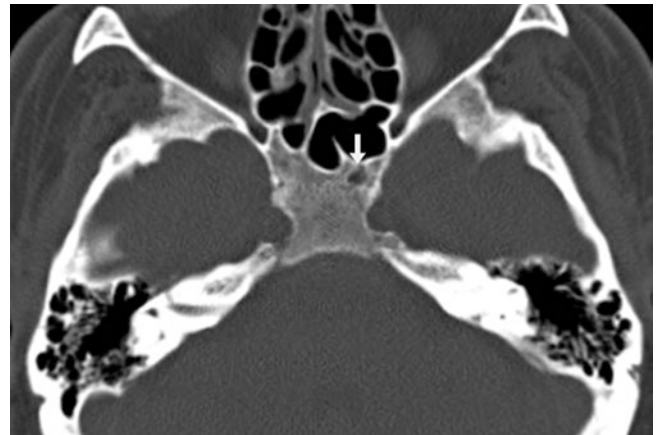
A 58 year old in whom on CT, focal hypotenuation (too small to measure a density) was noted (*arrow*) within the basisphenoid, likely from arrested pneumatization
